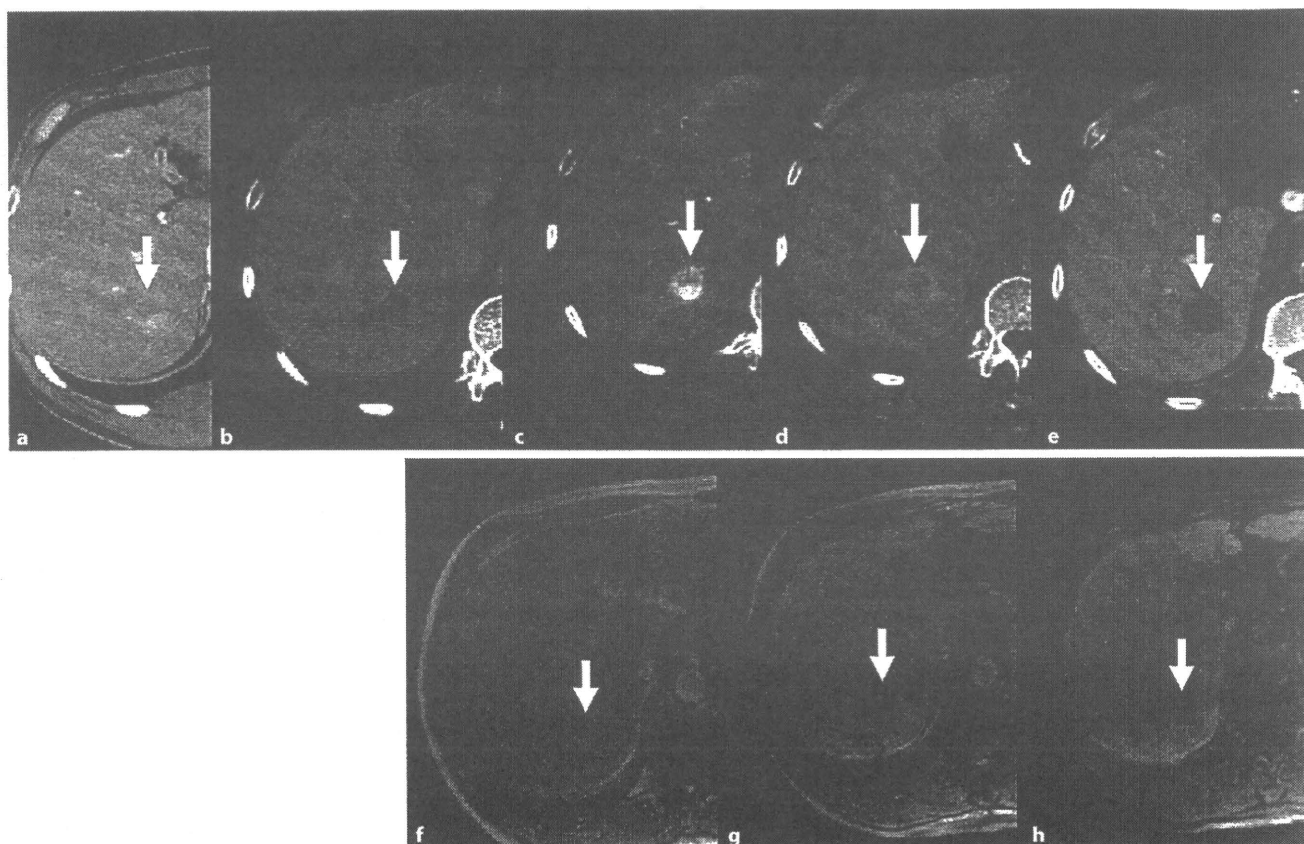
Representative case of hypervascular early HCC in a 64-year-old male. There is a hypervascular nodule 1.8 cm in diameter in segment 7 during the arterial phase in the dynamic CT scan (a) which becomes a low-density area during the equilibrium phase (b). CTHA revealed a hypervascular region (c) which becomes a ringed enhancement, a so-called 'corona enhancement'
